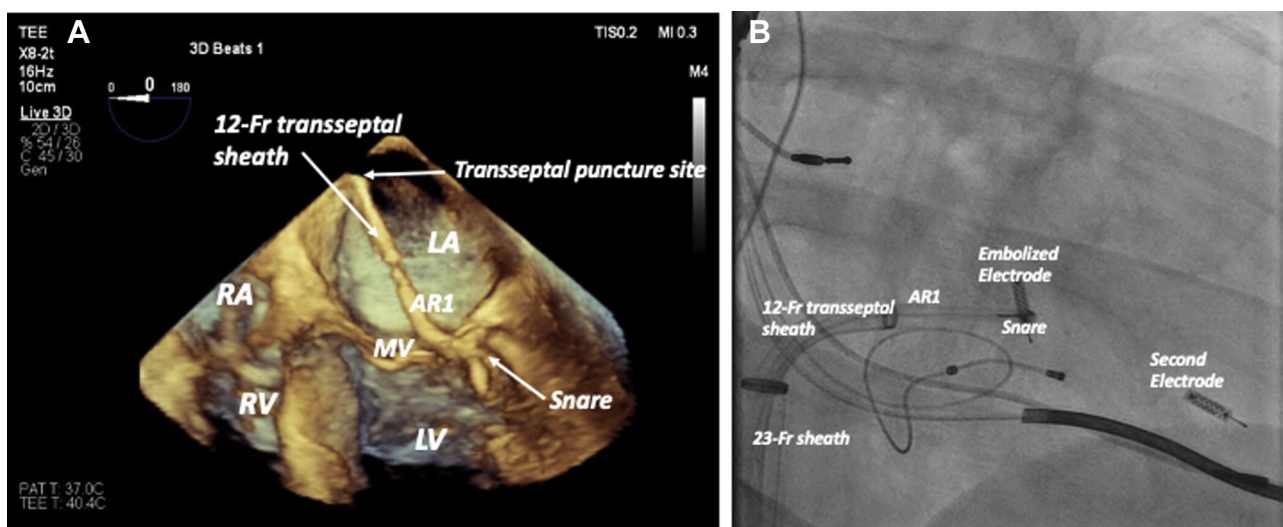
A: Three-dimensional transesophageal echocardiogram shows the angled coronary angiogram catheter (AR1) directed toward the basal anterolateral left ventricle (LV) where the embolized electrode is located. LA = left atrium; MV = mitral valve; RA = right atrium; RV = right ventricle. B: Right anterior oblique projection view of retrieval of the embolized electrode. The electrode was successfully snared and retrieved into the 12F transseptal sheath.
